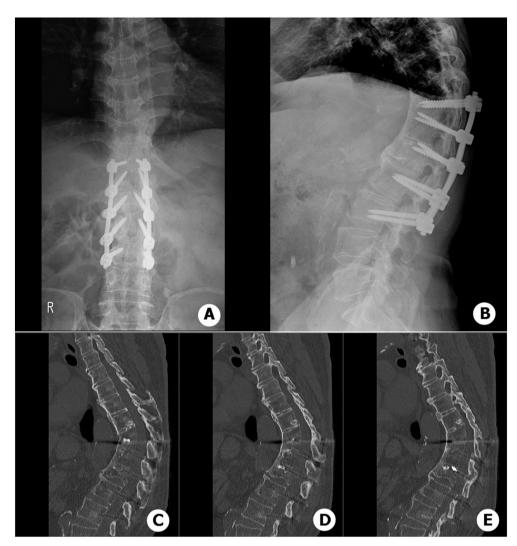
The simple radiograph and computed tomography which were taken at postoperative one year. The fracture line was not seen in the L1 vertebra body, which meant that the fracture was finally united.
